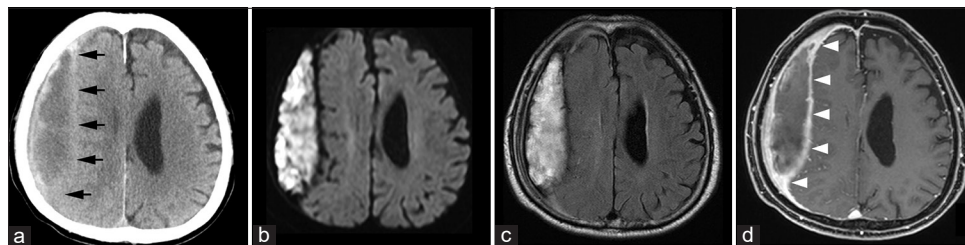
(a) Head computed tomography reveals a further increase in volume and a biconvex shape of the chronic subdural hematoma (black arrows). (b and c) Magnetic resonance imaging demonstrates an expanding subdural hematoma with no surrounding edema on fluid-attenuated inversion recovery and heterogeneous hyperintense signals corresponding to the expansive component of the subdural hematoma on diffusion-weighted imaging. (d) Postgadolinium T1-weighted image shows enhancement of the thickened hematoma capsule (white arrowheads).
